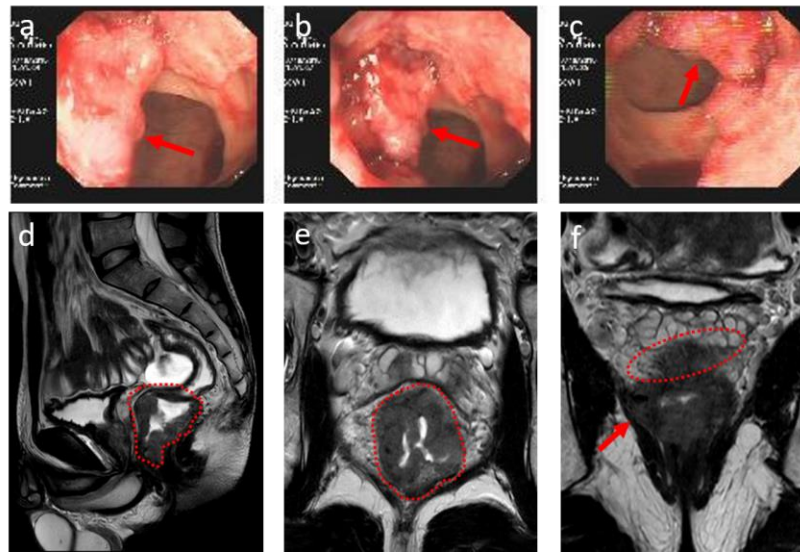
Colonoscopy and MRI examination before chemotherapy. a, b and c were tumor uplift under the colonoscopy field of view, with a rough surface and bleeding; d and e were MRI findings in coronal and transverse positions; f. The boundary between the tumor and the levator ani muscle on the right was unclear, and the lesion edge was rough at the intrinsic muscle level.
